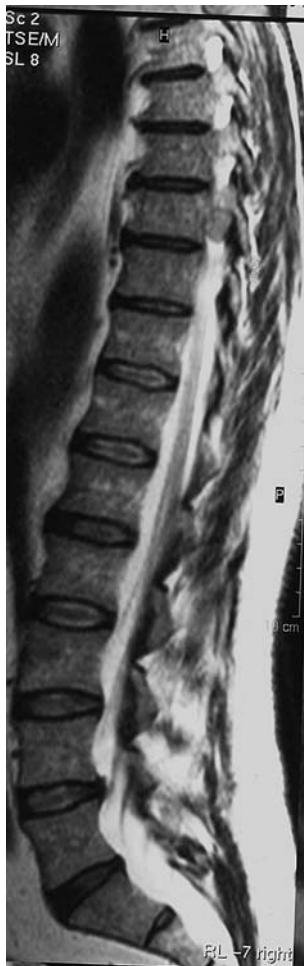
Sagittal T2-weighted MRI showing T9–T10 right intervertebral foramen occupied by the tumor
